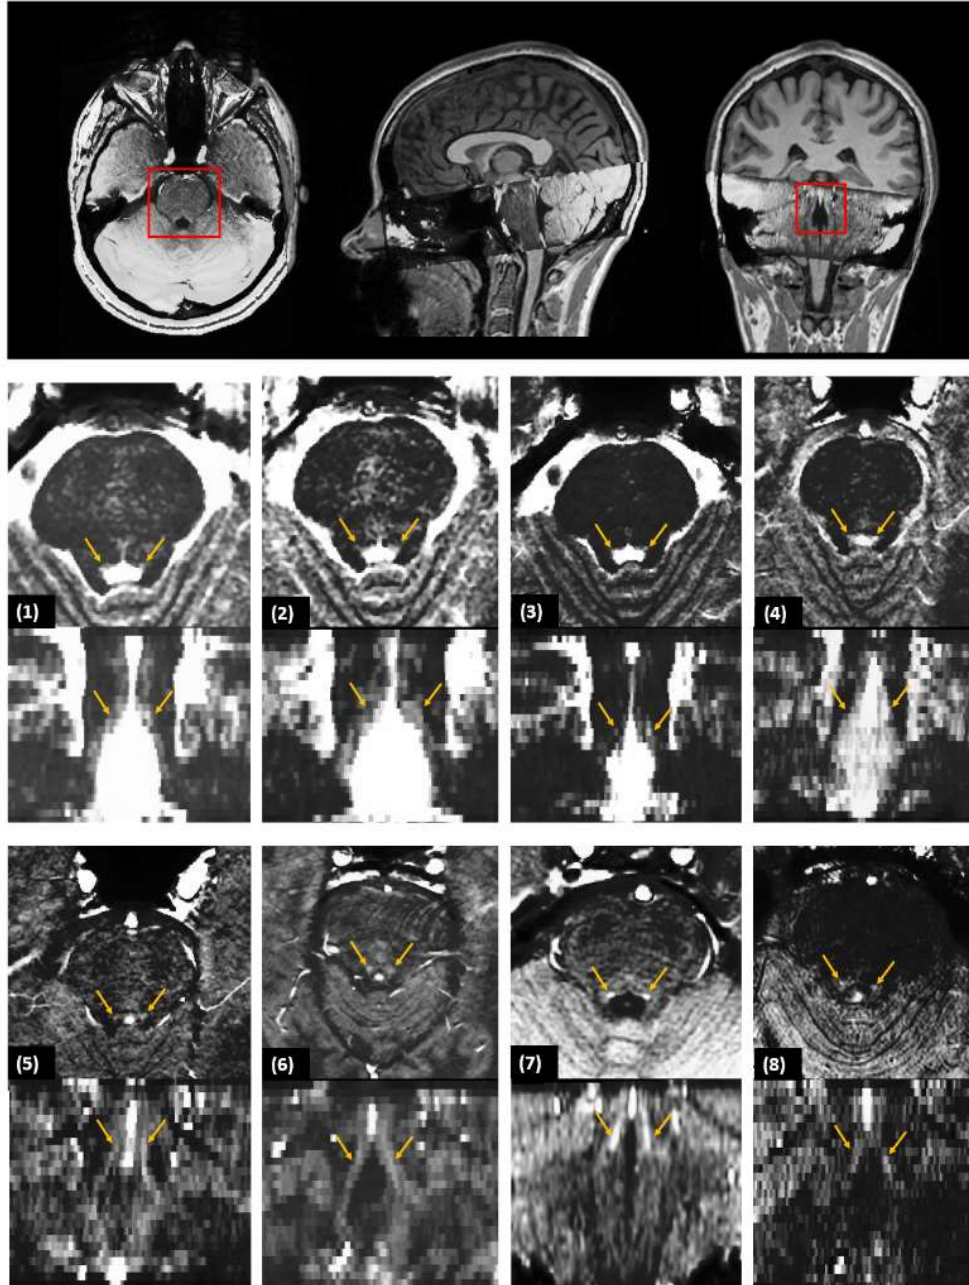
Visualization of the locus coeruleus (LC) with the different Magnetization Transfer Turbo-FLASH (MT-TFL) MRI sequences tested. Parameters of the sequences are: (1) $FA = 8^\circ$, $TE = 4$ ms and $TR = 81$ ms ; (2)
